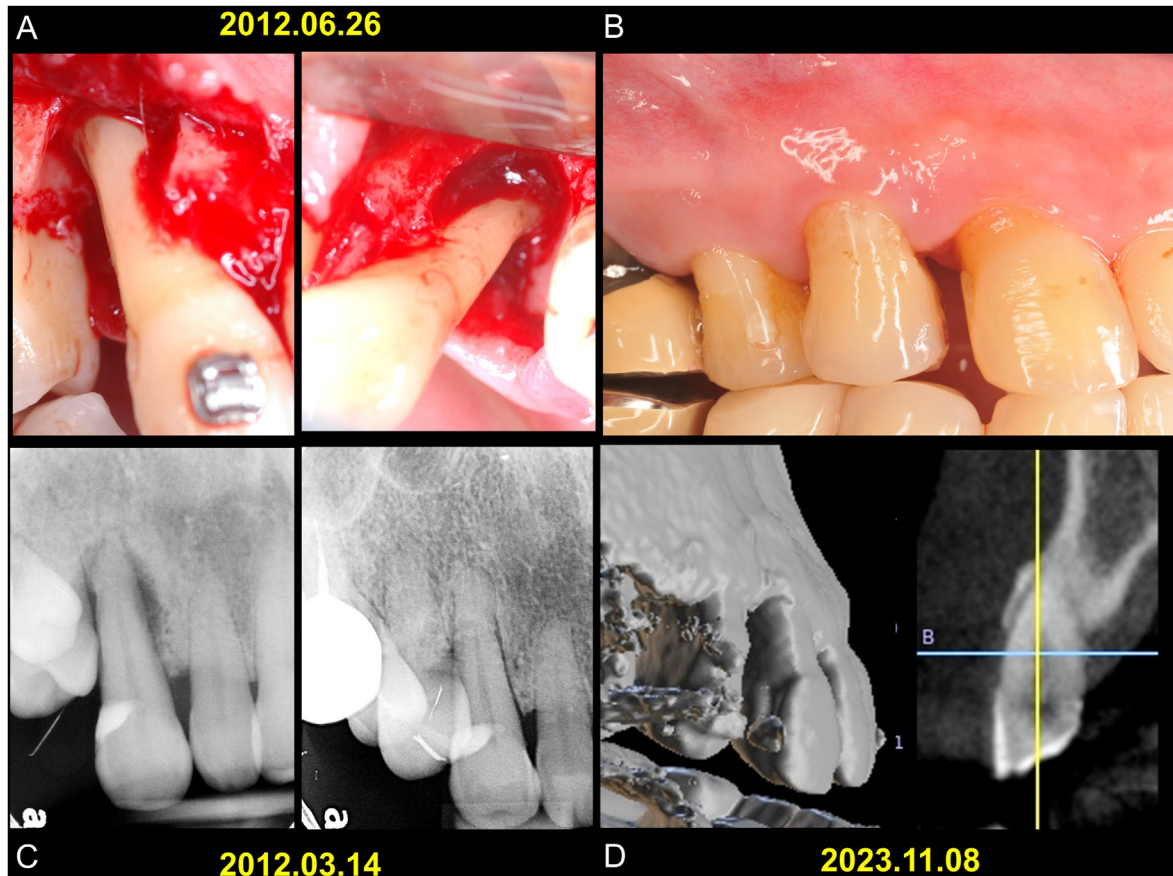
Case 1 is a 40-year-old female patient with Stage IV periodontitis and complained of diastema and flare out of anterior teeth. During surgery, an intrabony defect extending close to the pulp at both the buccal and palatal sides of tooth #13 was noted (Fig. 2A). Regenerative therapy was subsequently performed to restore the lost periodontal tissue. The clinical probing depth of tooth #13 decreased from 11 mm to 5 mm at the last follow-up appointment (Fig. 2B). Both periapical radiographs taken initially and at the last follow-up (Fig. 2C) and a cone-beam computed tomography (CBCT) scan conducted 11.5 years after periodontal regenerative treatment (Fig. 2D) revealed significant filling of the intrabony defect at both the buccal and palatal sides, accompanied by an increase in bone density.
